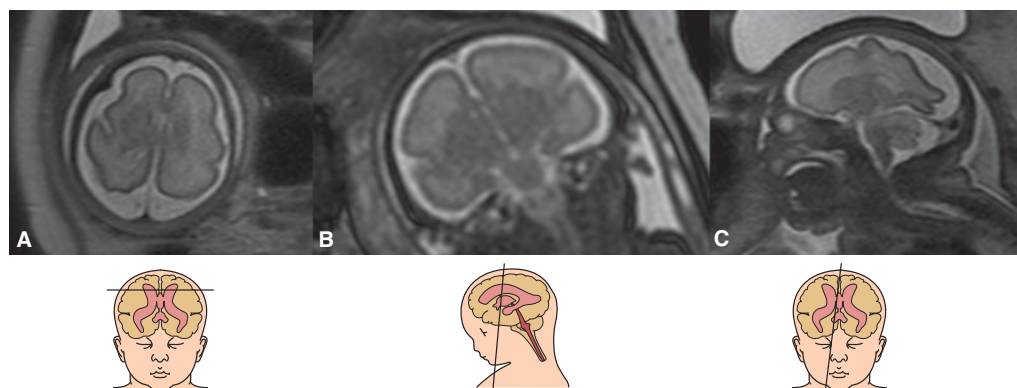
T2-weighted magnetic resonance imaging (MRI) at 31 postmenstrual weeks in a fetus with microcephaly and simplified cortical pattern. Axial (A), coronal (B), and sagittal (C) planes show sloping forehead and increased extra-axial fluid with abnormal, simplified sulcation pattern. (Courtesy of Dr. Atıl Yuksel and Dr. Arda Lembed, Istanbul, Turkey.)
